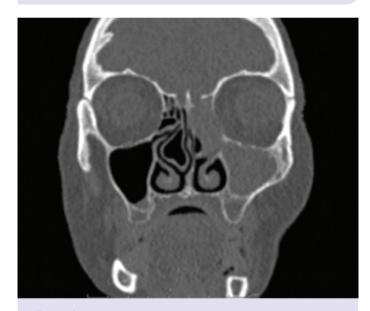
Coronal section computed tomographic (CT) imaging of B-cell non-Hodgkin lymphoma.
